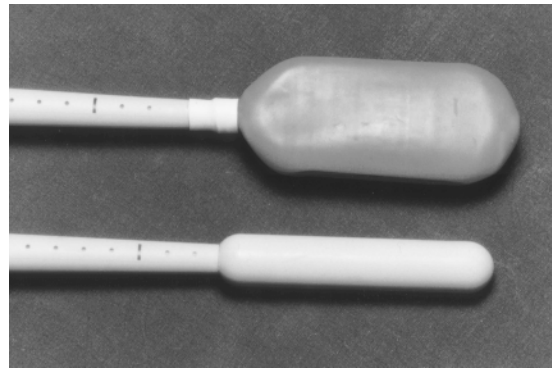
Photograph shows endoluminal coils for endorectal (top) and endoanal (bottom) MR imaging.
